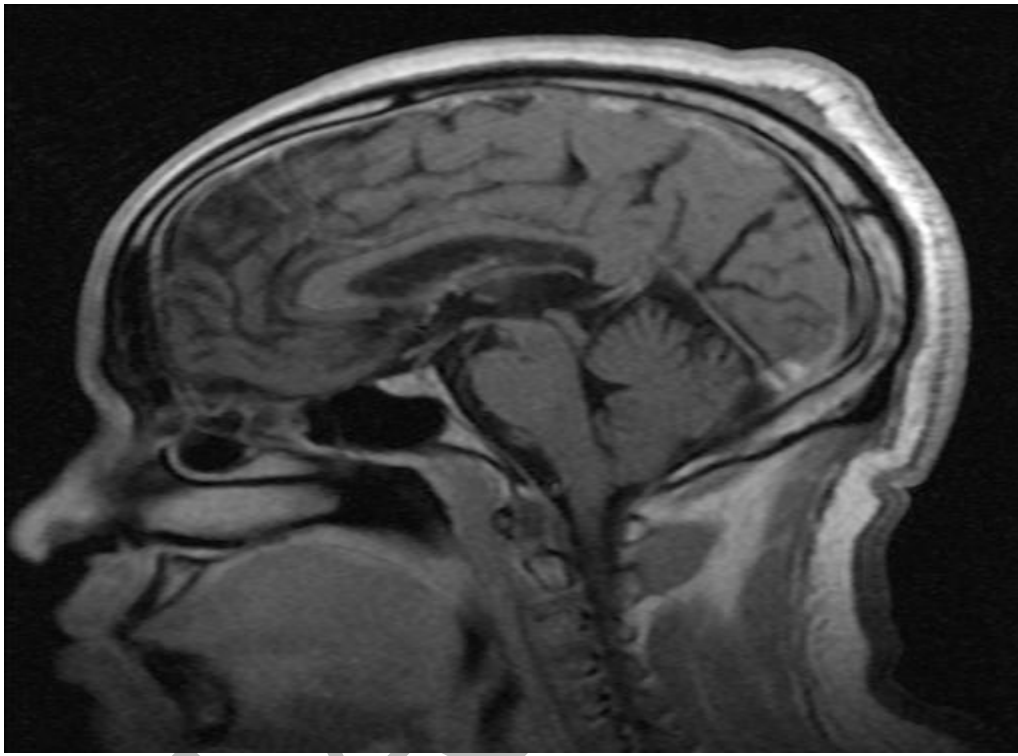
Sagittal view of brain MRI showing generalised cerebral and hypothalamic atrophy
